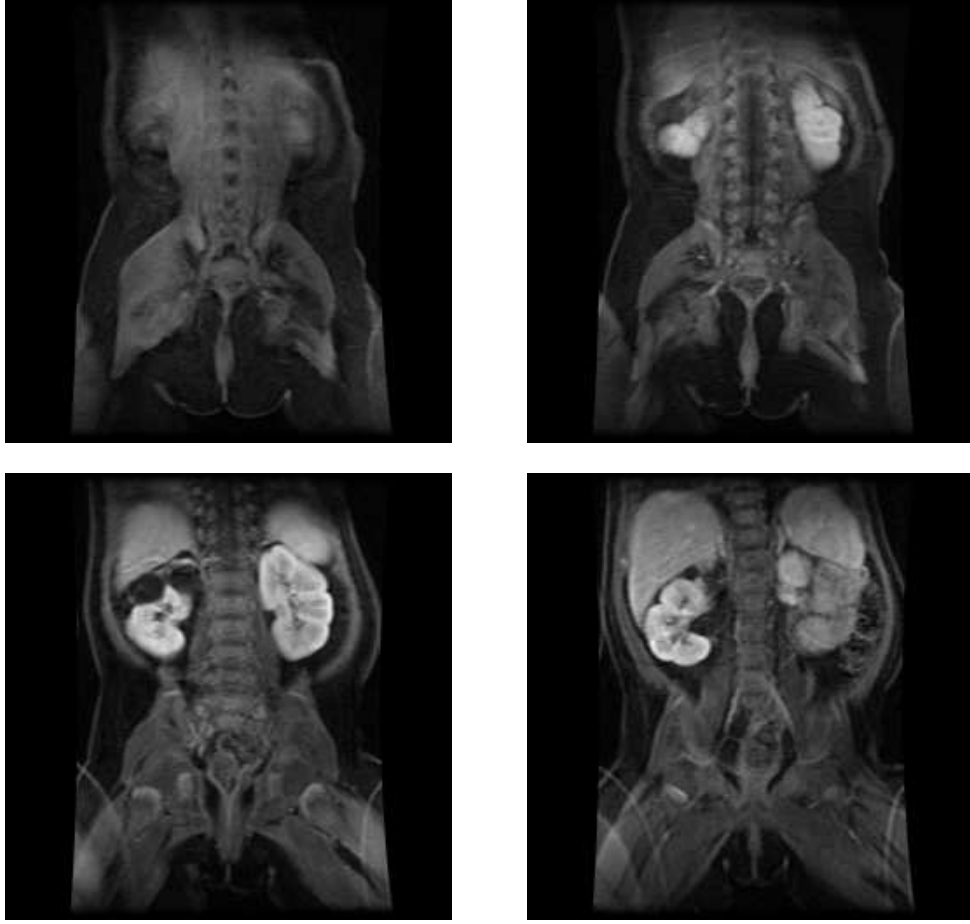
2D samples of 4D data set B of MRI images showing an enhanced human kidney cortex, spleen and liver obtained for a urography study.
